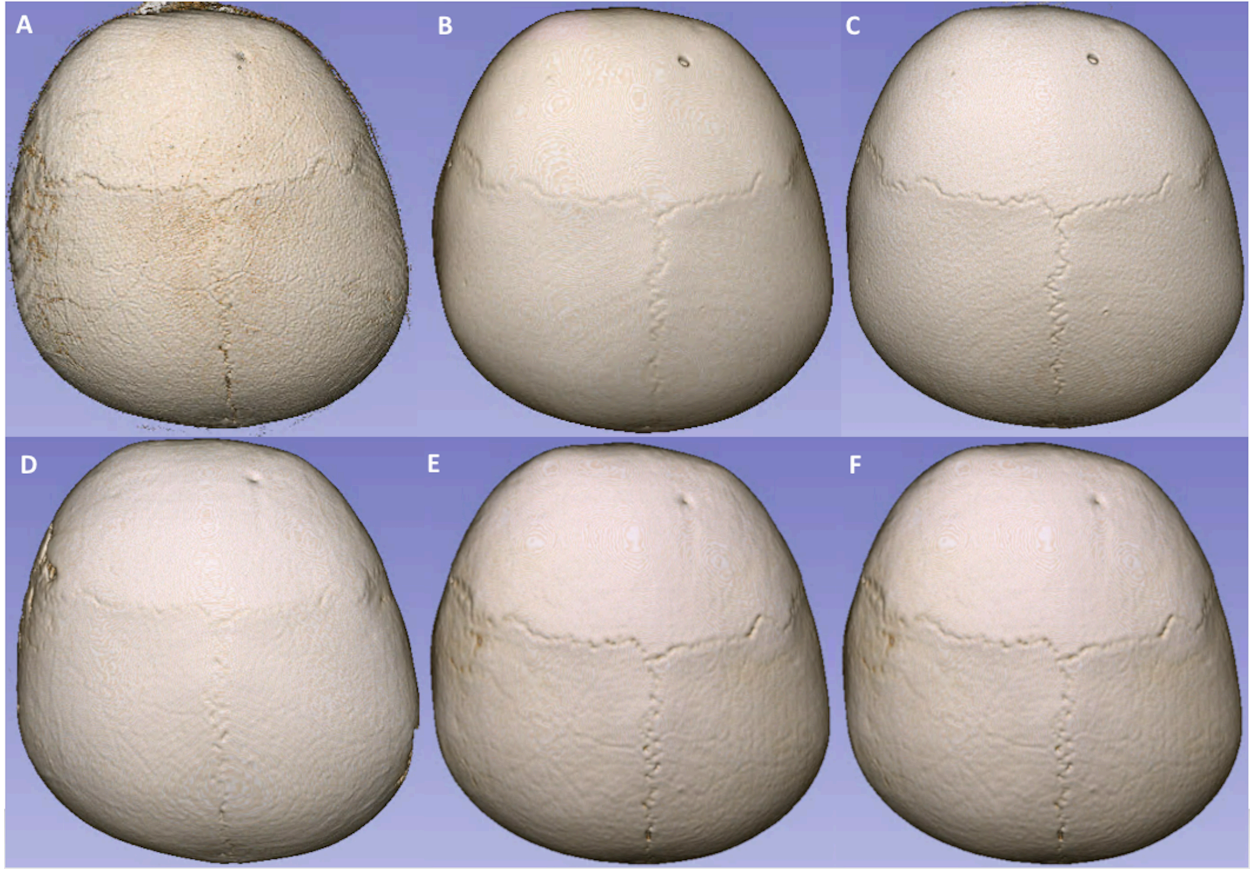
3D surface rendered cranial bone image from a participant (4.8-year-old, male) using iMR (A), CT (B), BM3D filtered CT (C), pCT<sub>NetWH</sub> (D), pCT<sub>NetBA</sub> (E), and the pCT<sub>Com</sub> (F).
